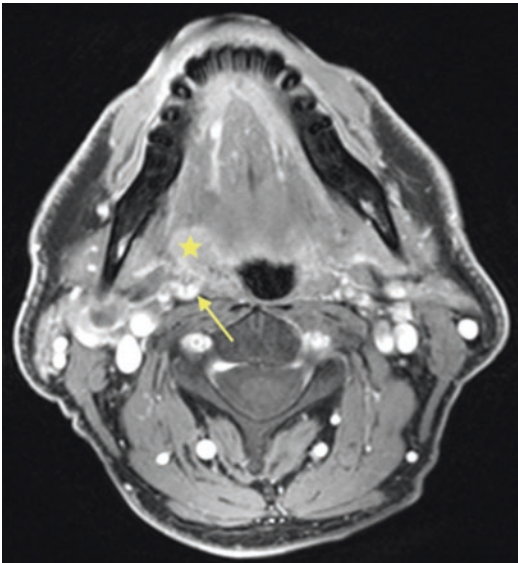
Feeding vessels. Preoperative imaging can identify tumor-feeding vessels as large as the named cervical arterial branches. Displayed is an MRI, T1 fat-saturated post-contrast, scan of a patient with glossopharyngeal fold squamous cell carcinoma (*star*) undergoing evaluation for TORS resection. This image demonstrates a large caliber vessel (*arrow*) arising from the facial artery
